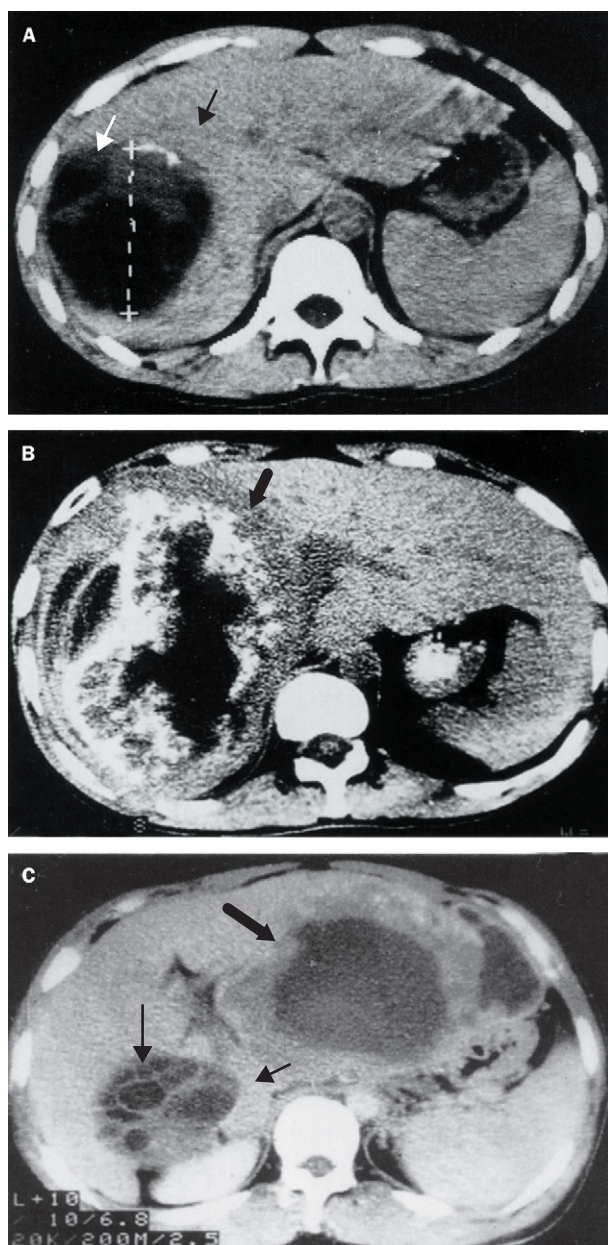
Abdominal CT scans of patients with hepatic echinococcosis
